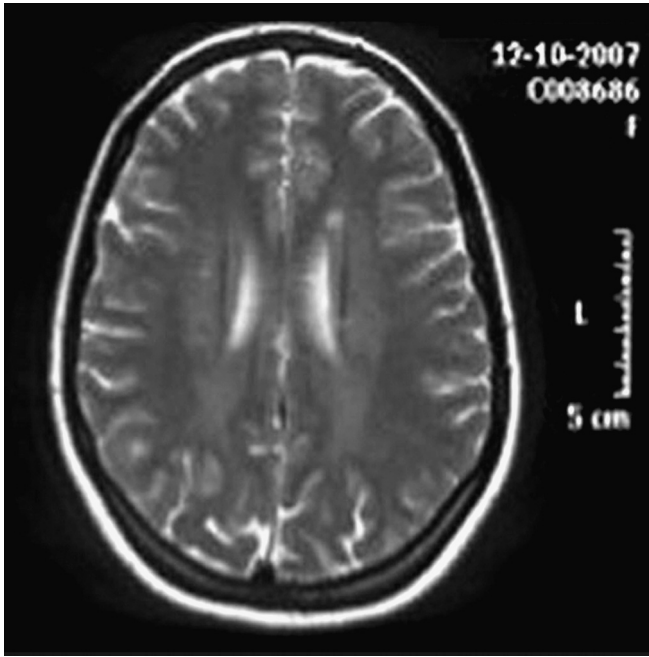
Axial brain T2-MRI showing periventricular hyperintense lesions coupled with a moderate diffuse white matter hyperintensity.
